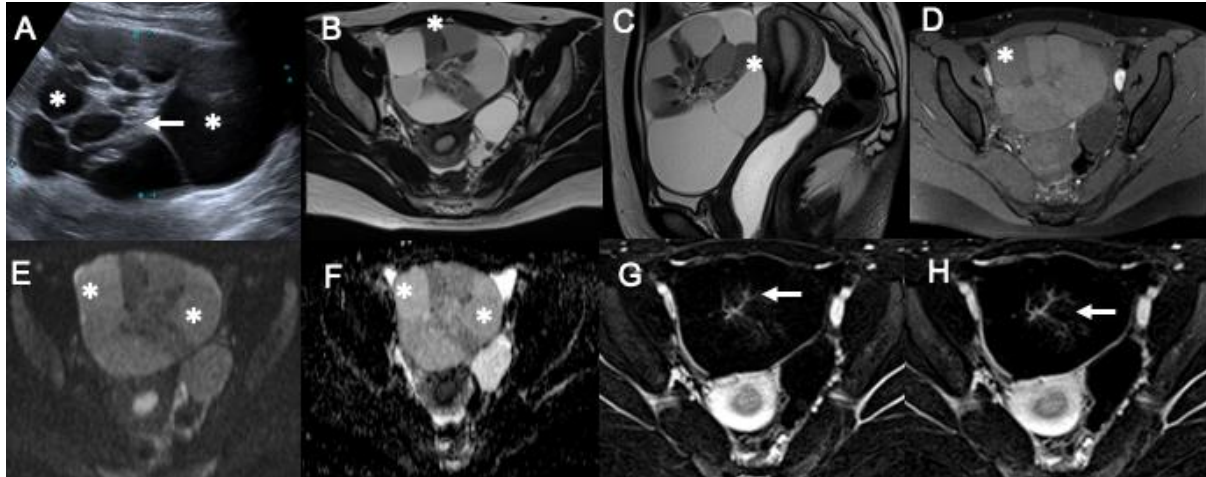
MRI of a struma ovarii. US (A) shows a multilocular cystic lesion with locules of different echogenicity (asterisks) and thickened septations (arrow). On MRI, the locules have variable signal intensity. Still, characteristically there are some with low signal on T2-weighted (B, C) and T1-weighted images (D), as well as mild restricted diffusion (E, F) due to high content on proteins. The septations show mild enhancement on early (G) and delayed (H) enhancement.
